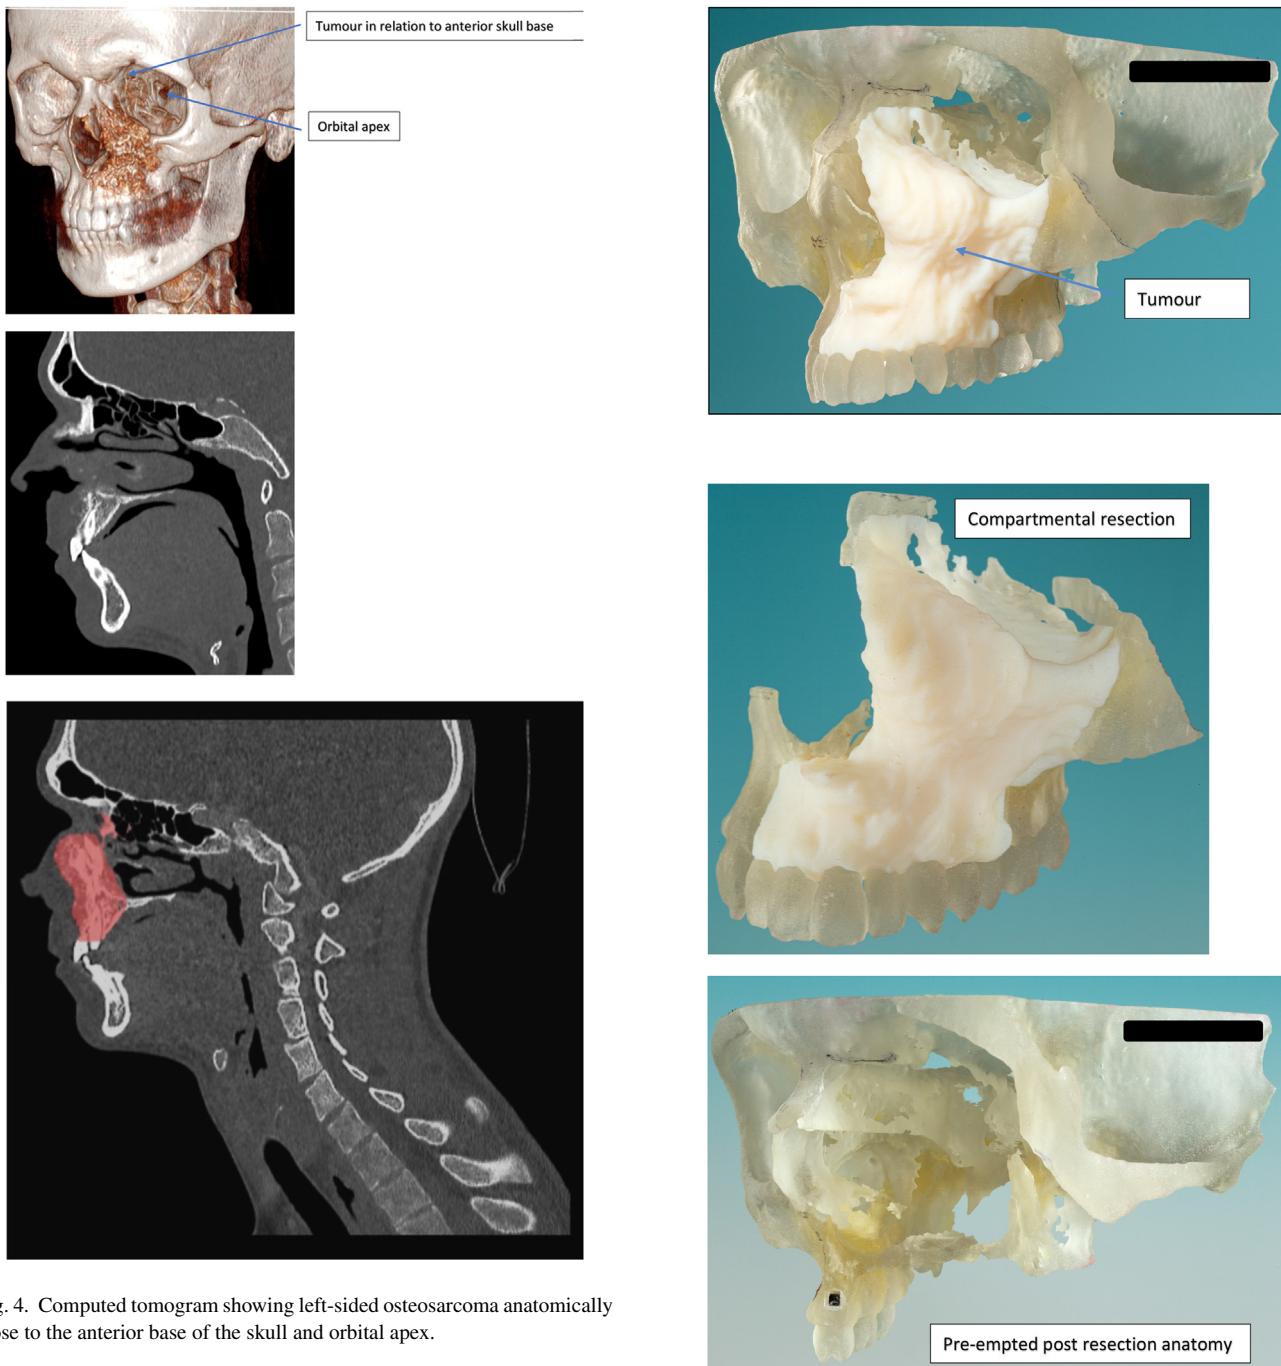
Computed tomogram showing left-sided osteosarcoma anatomically close to the anterior base of the skull and orbital apex.
